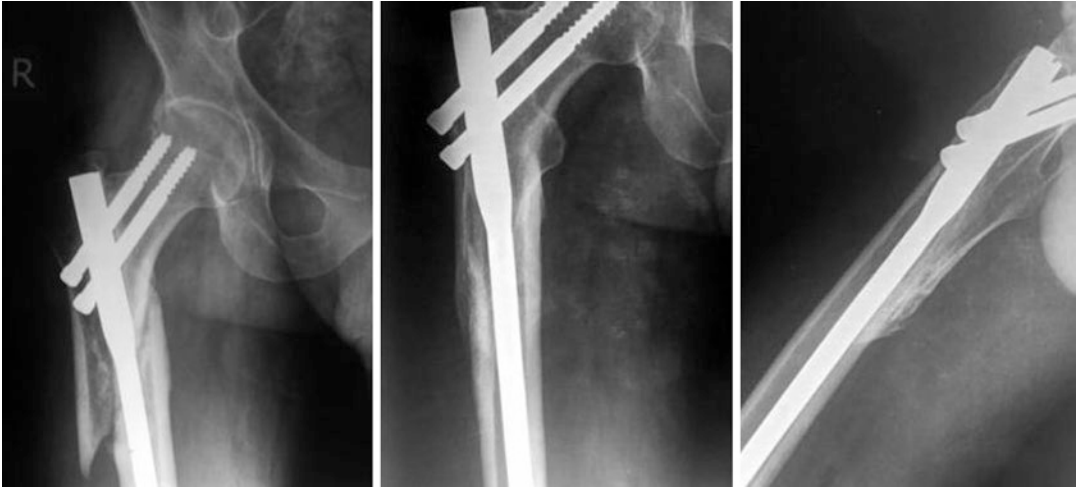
Left: Surgically intervened nonunion proximal femur band. Middle: Follow-up anteroposterior radiograph. Right: Lateral radiograph showing union
